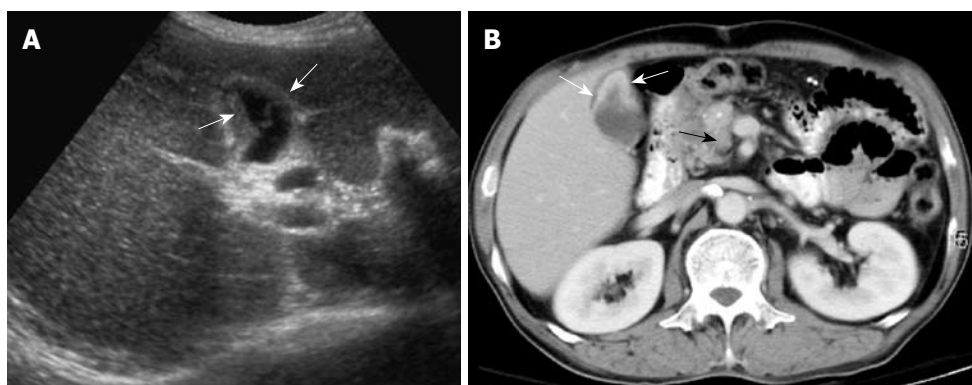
A 61-year-old man with dull right upper abdominal pain for 3 wk. A: US showed a relatively small gallbladder with focal wall thickening (arrows), which was misinterpreted initially as inadequate gallbladder distension; B: Contrast-enhanced CT was done because of persistent abdominal discomfort. It revealed relatively poor distension of the gallbladder with prominent enhancement of the focally thickened gallbladder wall (white arrows) and celiac lymph node metastasis (black arrow).
